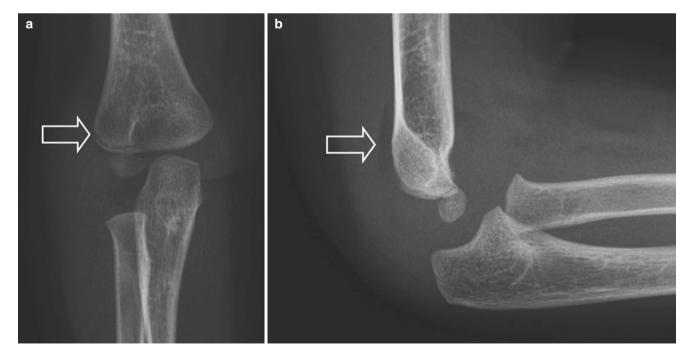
Two-year-old child who fell out of a high chair. (a) AP radiograph of the elbow shows a lateral condyle fracture (arrow). (b) On the lateral radiograph the fracture cannot be seen, but there clearly is a posterior fat-pad sign (arrow)
